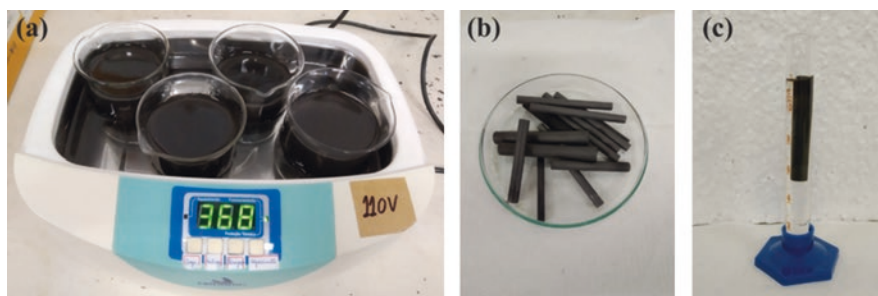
Cleaning the graphite rods by ultrasonic (a), clean graphite rods after agitation (b), and pretreatment of the graphite rods with acid (c)
